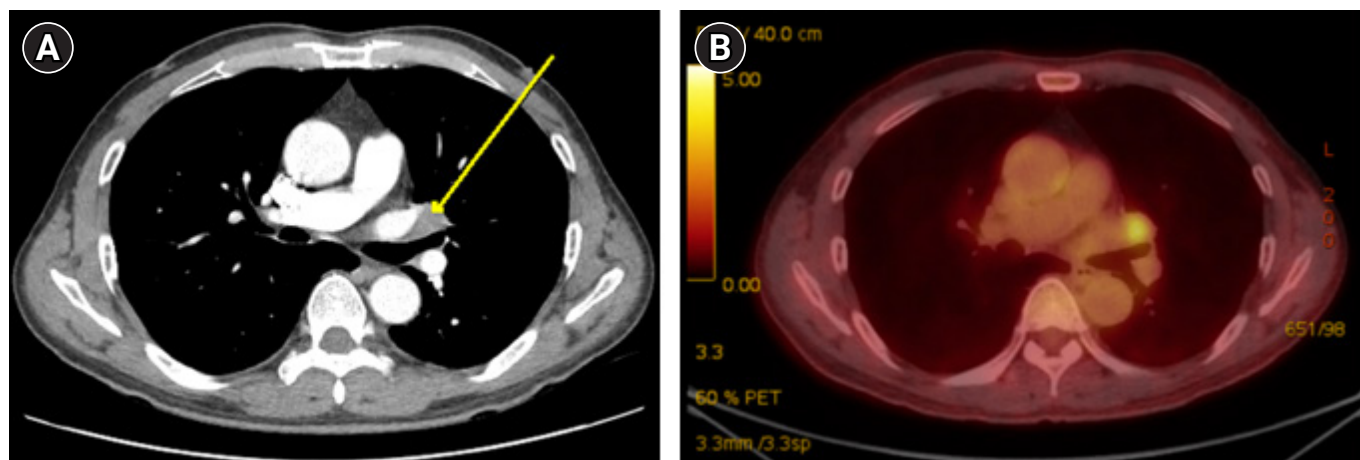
(A) Computed tomography and (B) positron emission tomography images showing an enlarged left interlobar lymph node (arrow).
